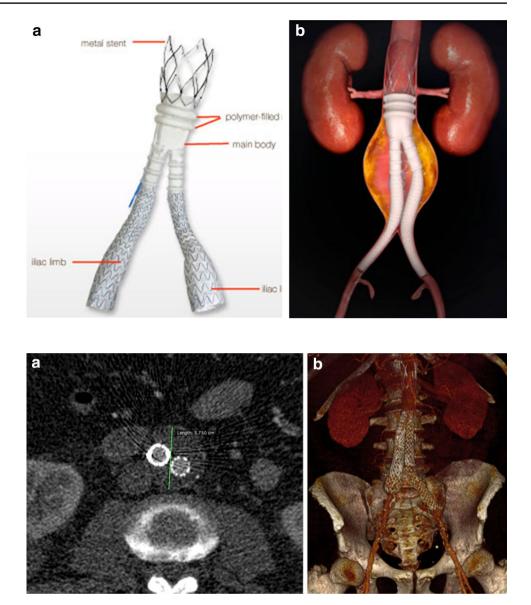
Computed tomography (CT) scan performed after 24 months reveals reduction of the sac diameter (G); volume rendering (VR) reconstruction of the same examination (b)
